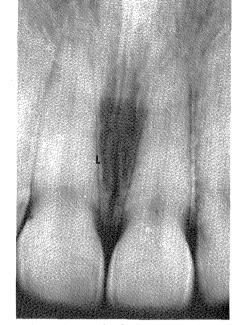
Radiograph of upper central incisor area. *L*, Lamina dura.
